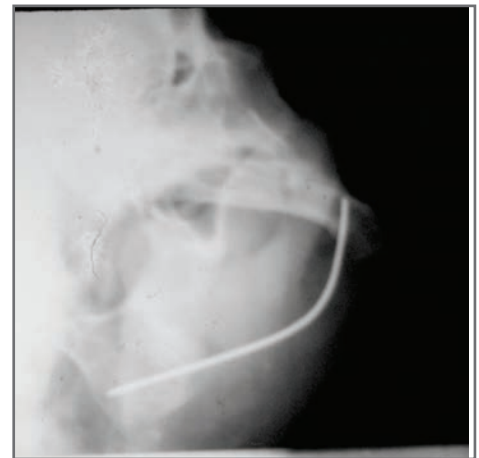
Radiograph showing the Steinmann Pin in position.
